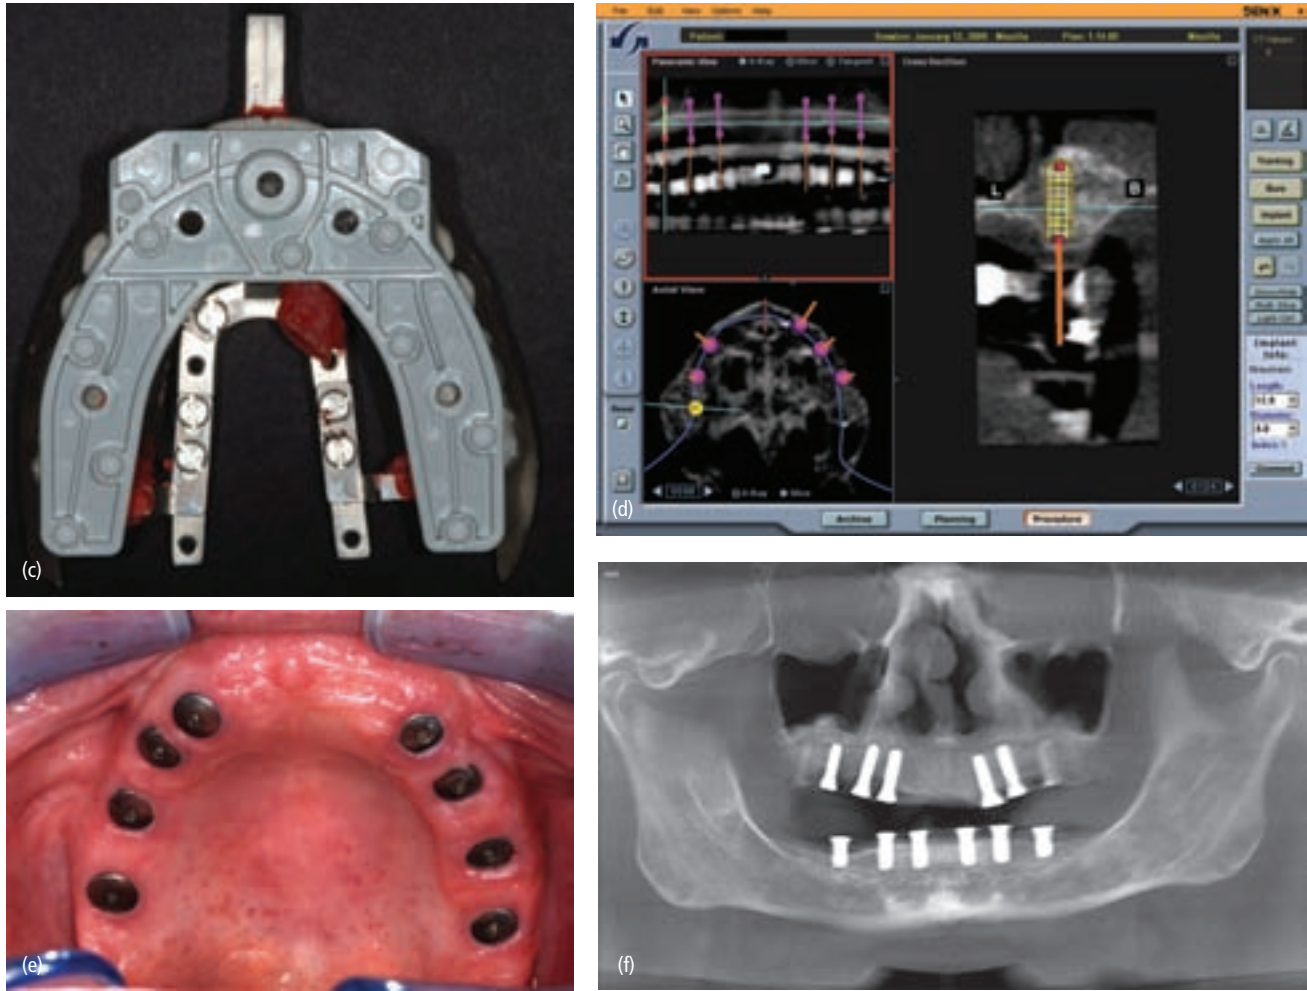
(cont'd) (c) Before the CBCT is exposed, a horseshoe containing nine ceramic fiducials is luted to the wax-up shown in (b). These elements are placed on the reduced-diameter implants before the CBCT is exposed. (d) The CBCT has been fed into the CPU of the navigational device. Marking the fiducials in the planning program eliminates any distortion. Digital avatars are then placed into the planning program and appropriately related to the available bone and the proposed final restorations modeled here by the barium-impregnated representations of the teeth. (e) Navigation is then used for implant placement (described in detail in other areas of this chapter). Seen here is the final implant placement in the maxilla. (f) A panoramic film of the implant placement approximately 30 days after surgery. Successful implant orientation was possible in this case because of an abundant amount of keratinized tissue in the implant sites and the accuracy with which the implants are placed using navigation techniques.
